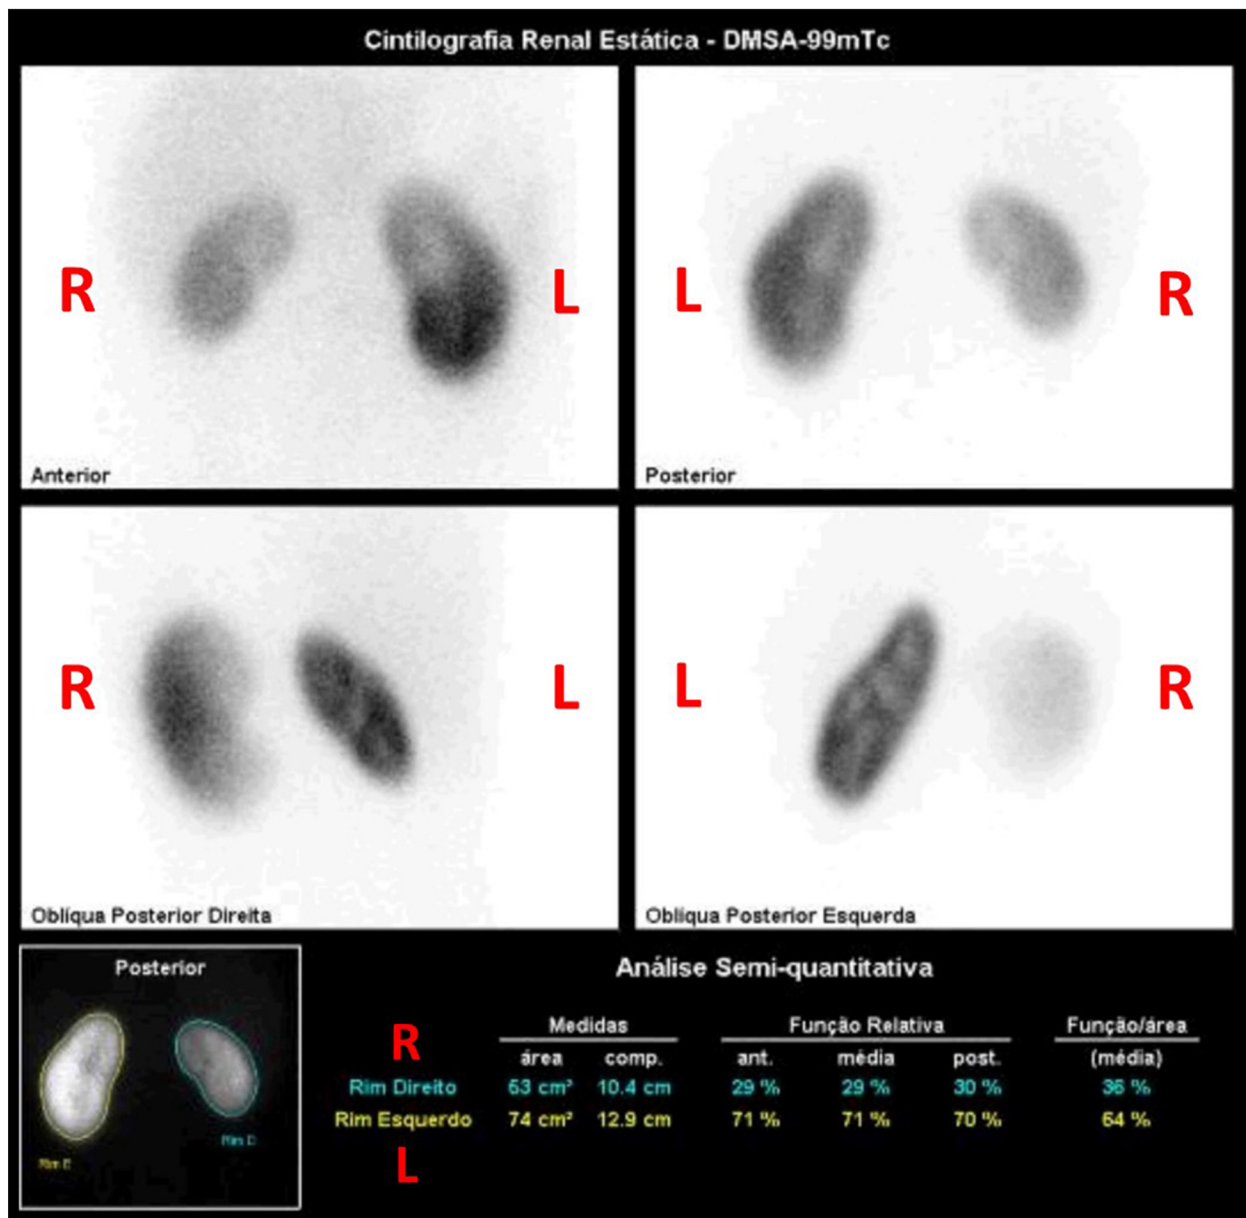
Renal scintigraphy with 99mTc-DMSA. Preserved global renal tubular function. Right kidney (R) with moderate tubular function deficit. Absence of cortical scars. Left kidney (L) with preserved tubular function and no evidence of cortical scarring.
